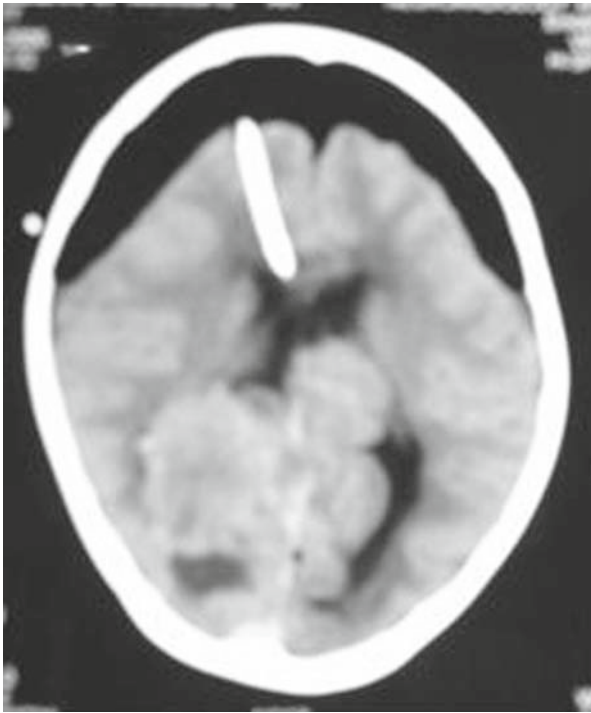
Computed tomography scan, showing bifrontal pneumocephalus, with external ventricular drain in situ
